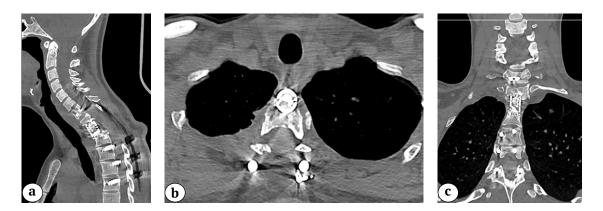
CT images 12 month post-op: no signs of hydatid disease recurrence, anterior fusion formation Th1-3 with sagittal cervico-thoracic balance correction: a – sagittal view; b – axial view; c – frontal view
